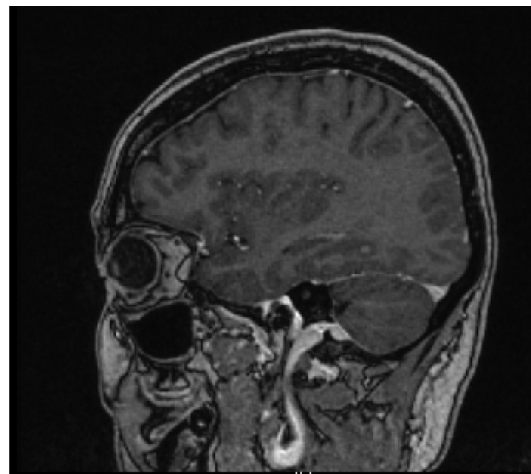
Brain MRI. Three millimeter enhancing focus associated with internal microhemorrhages at the right temporal lobe suspicious for cerebral metastasis.
